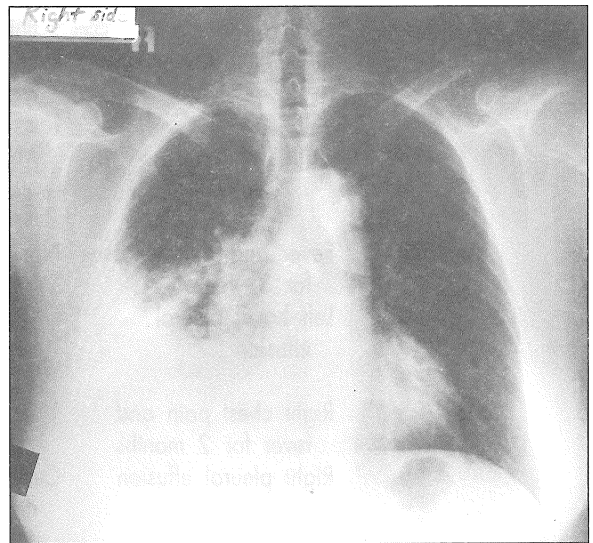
(a): Chest radiograph of patient 1 showing right pleural effusion
